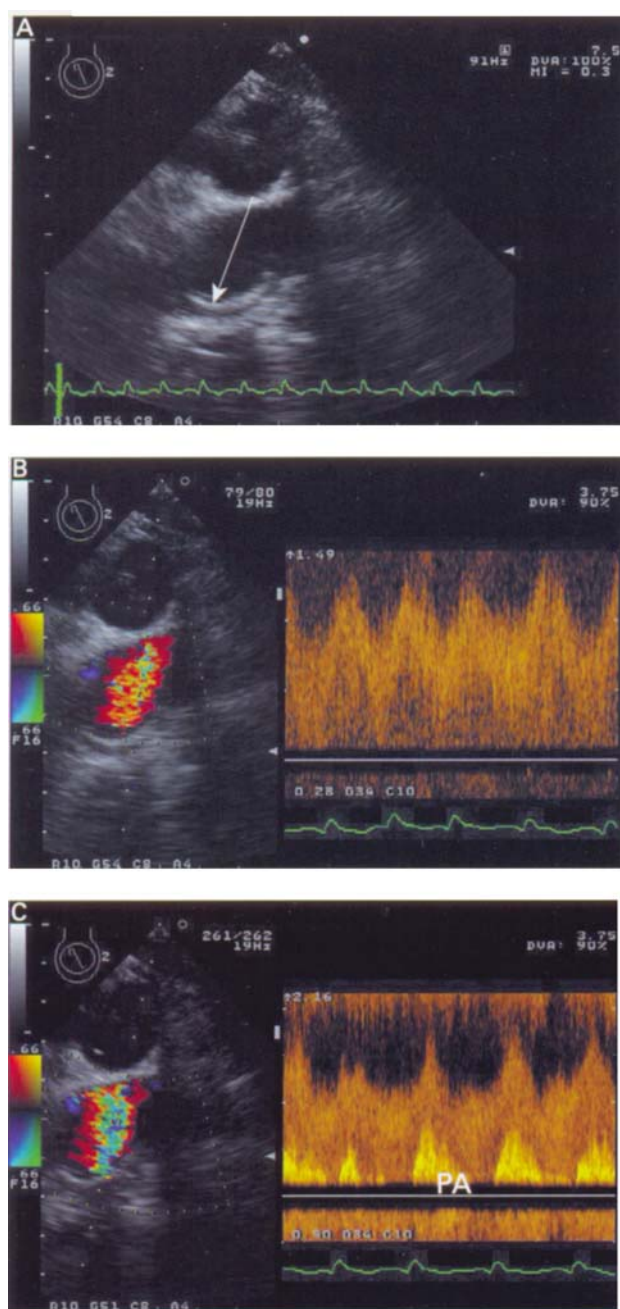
Ascending aortic outflow cannula of a non-pulsatile left ventricular assist device (LVAD; arrow), imaged in (A) the mid-oesophageal long axis view. (B) Pulsed wave Doppler shows continuous but wavelike flow due to left ventricular ejection assisting LVAD filling. (C) Continuous wave Doppler shows overlying systolic pulmonary artery flow (PA). Note the time synchrony to the peaks in LVAD outflow velocity.
